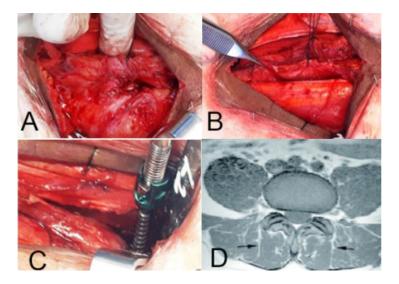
A-C: Using finger blunt dissection to enter the natural cleavage line between the multifidus and the longissimus muscle. D: This plane is demonstrated in MRI by the black arrow.
